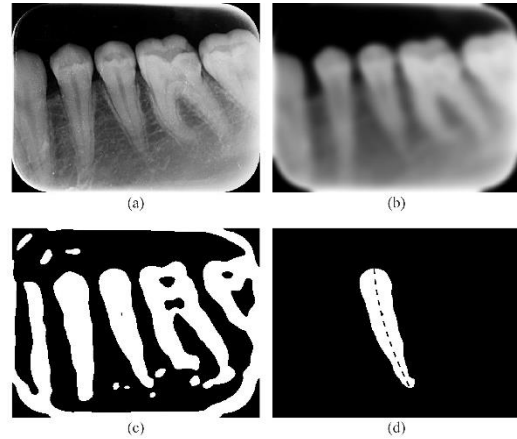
Midline detection for a single-rooted tooth: (a) the original radiograph; (b) the preprocessed radiograph; (c) the binarized radiograph; (d) the selected single-rooted tooth (the tooth midline is shown as a dashed black line).
